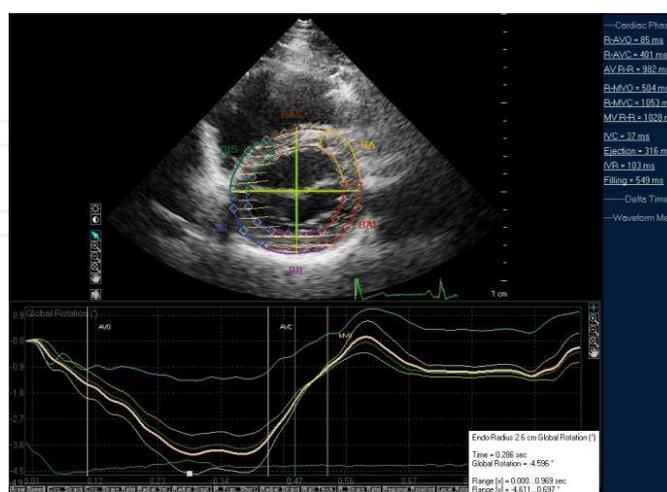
Rotation by speckle tracking echocardiography. The curves represent rotation in subendocardial, mural and subepicardial layers at the basal left ventricular level from parasternal short axis view.
